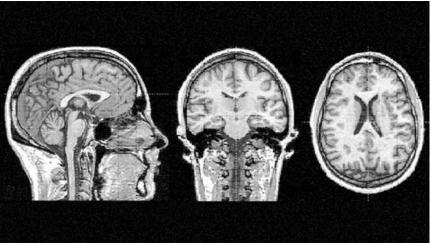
MRI scan of human brain. Calvert, 2012.
